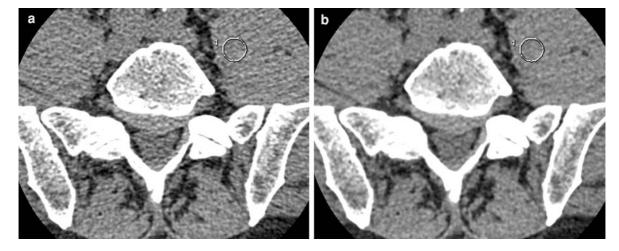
Transverse lumbar spine CT images reconstructed with standard filtered back projection (FBP) (a) and Adaptive Iterative Dose Reduction 3D (AIDR 3D) (b) in a 56-year-old man (1 mm slices, 135 kV, tube current modulation with noise index set at 8, DLP = 347 mGy cm). Note the noise reduction
